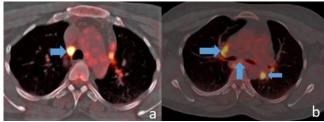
PETCT imaging showing an increased FDG uptake (SUVmax: 15,85) in the right paratracheal (a) and subcarinal and left hilar lymph nodes (b)
